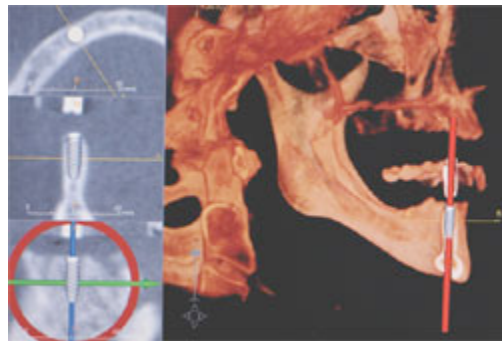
computed tomography scan can provide additional information to aid the implant team for proper placement of the implant(s).
